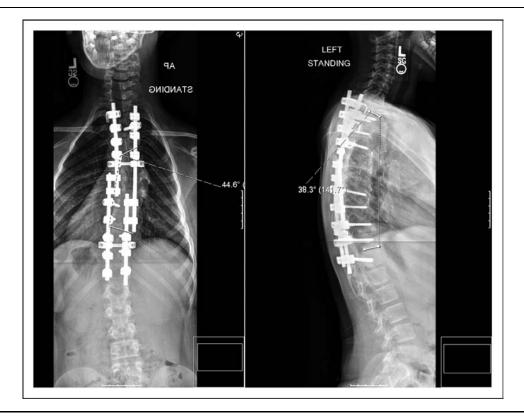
A radiograph surgical correction with posterior instrumentation of a dystrophic scoliosis
